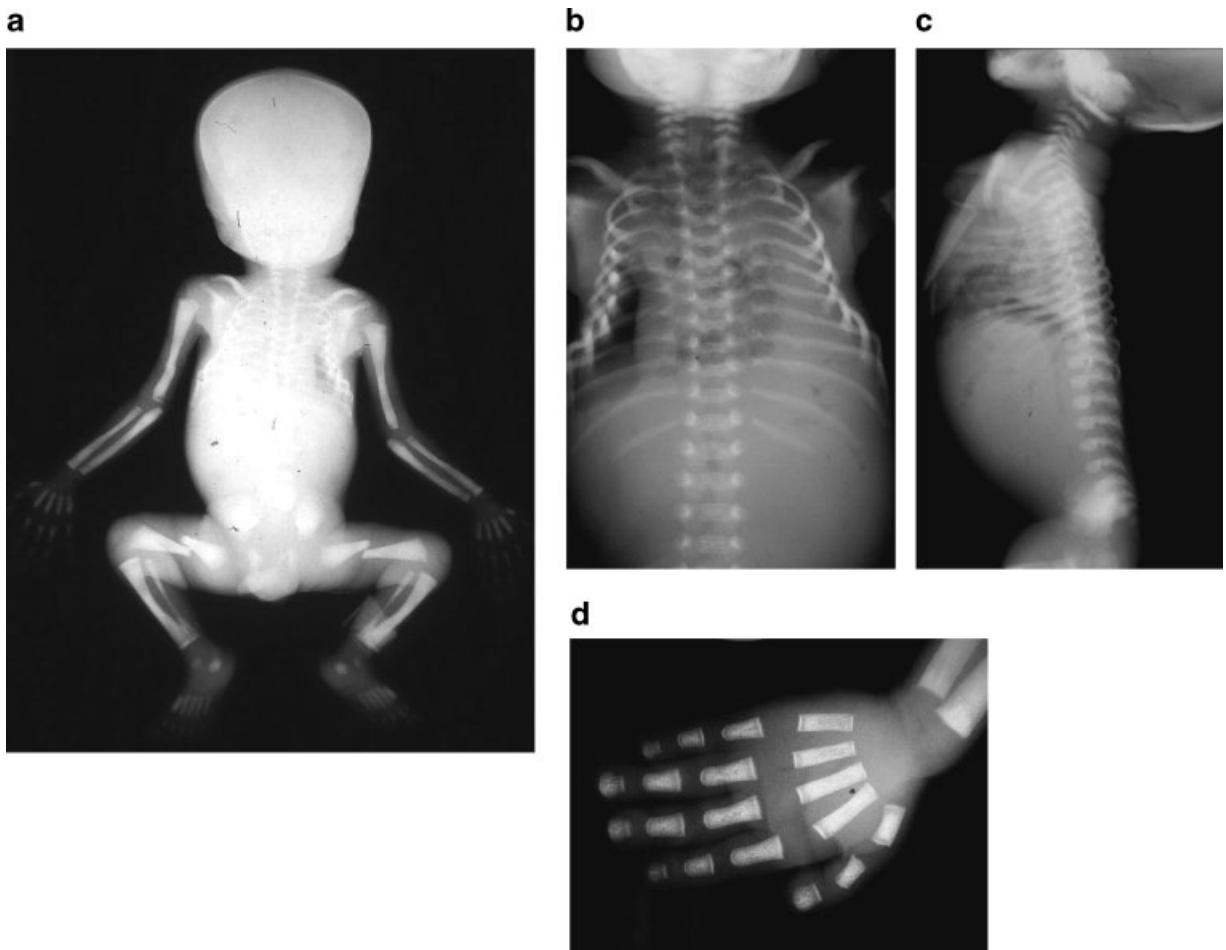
X-ray examination showing: (a) extreme sclerosis of the skull basis and of the facial bones. (b) Long bones and spine are irregularly shaped with insufficient metaphyseal wedging. Diaphyseal bones are extremely dense, with absent medullar canal. (c) The chondro-costal junction is angulated. (d) The first metacarpals and the distal phalanges are short, the latter showing a terminal tufting (mushroom profile).
